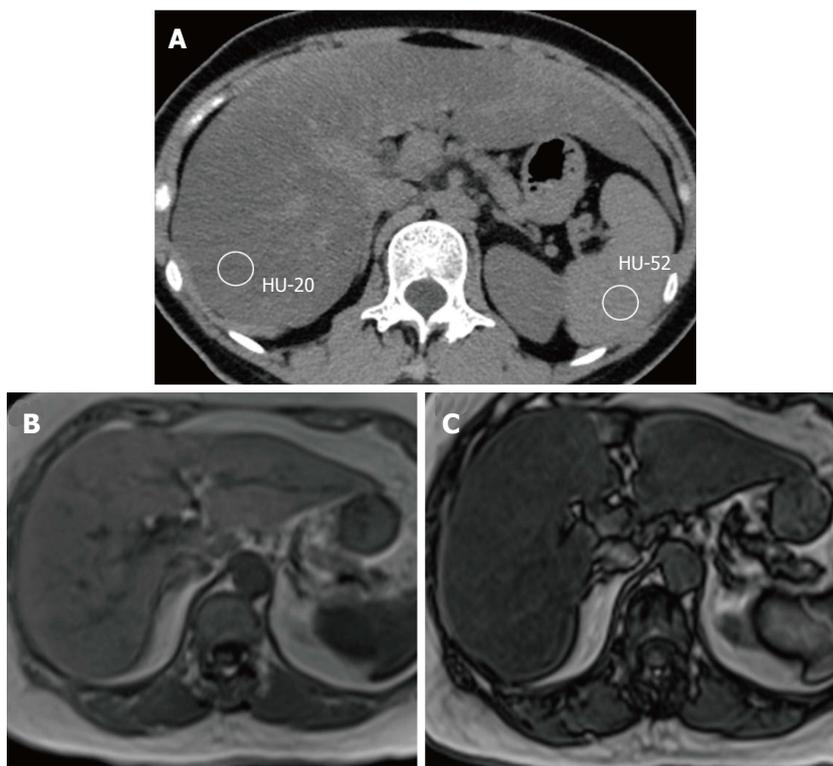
Diffuse hepatic steatosis is demonstrated here. In the non-enhanced computed tomography scan (A) the hepatic parenchyma has significantly lower attenuation than spleen. The out phase magnetic resonance imaging image (C) shows a drop in the hepatic signal intensity compared to that in the in-phase image (B).
